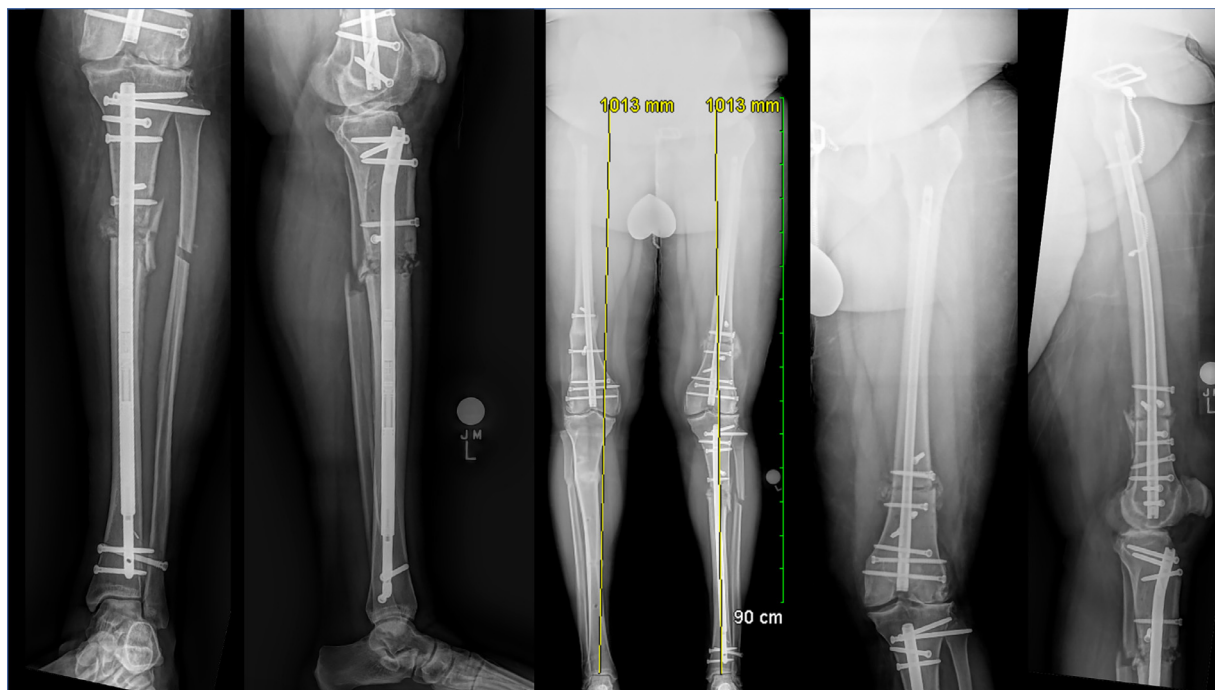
Radiographs of the bilateral lower extremities showing equalized leg lengths and greatly improved alignment that is now acceptable. There is excellent regenerate formation at the site of the osteotomy and lengthening.
